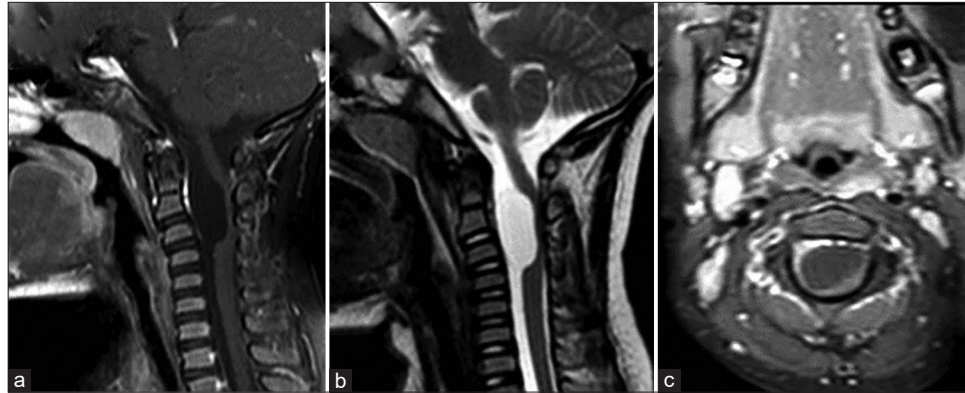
Preoperative magnetic resonance imaging (MRI), (a) sagittal T1-weighted MRI with contrast, (b) sagittal T2-weighted MRI, (c) Axial T1-weighted MRI with contrast, showing a cystic mass compressing the spinal cord suggestive of a compressive arachnoid cyst.
